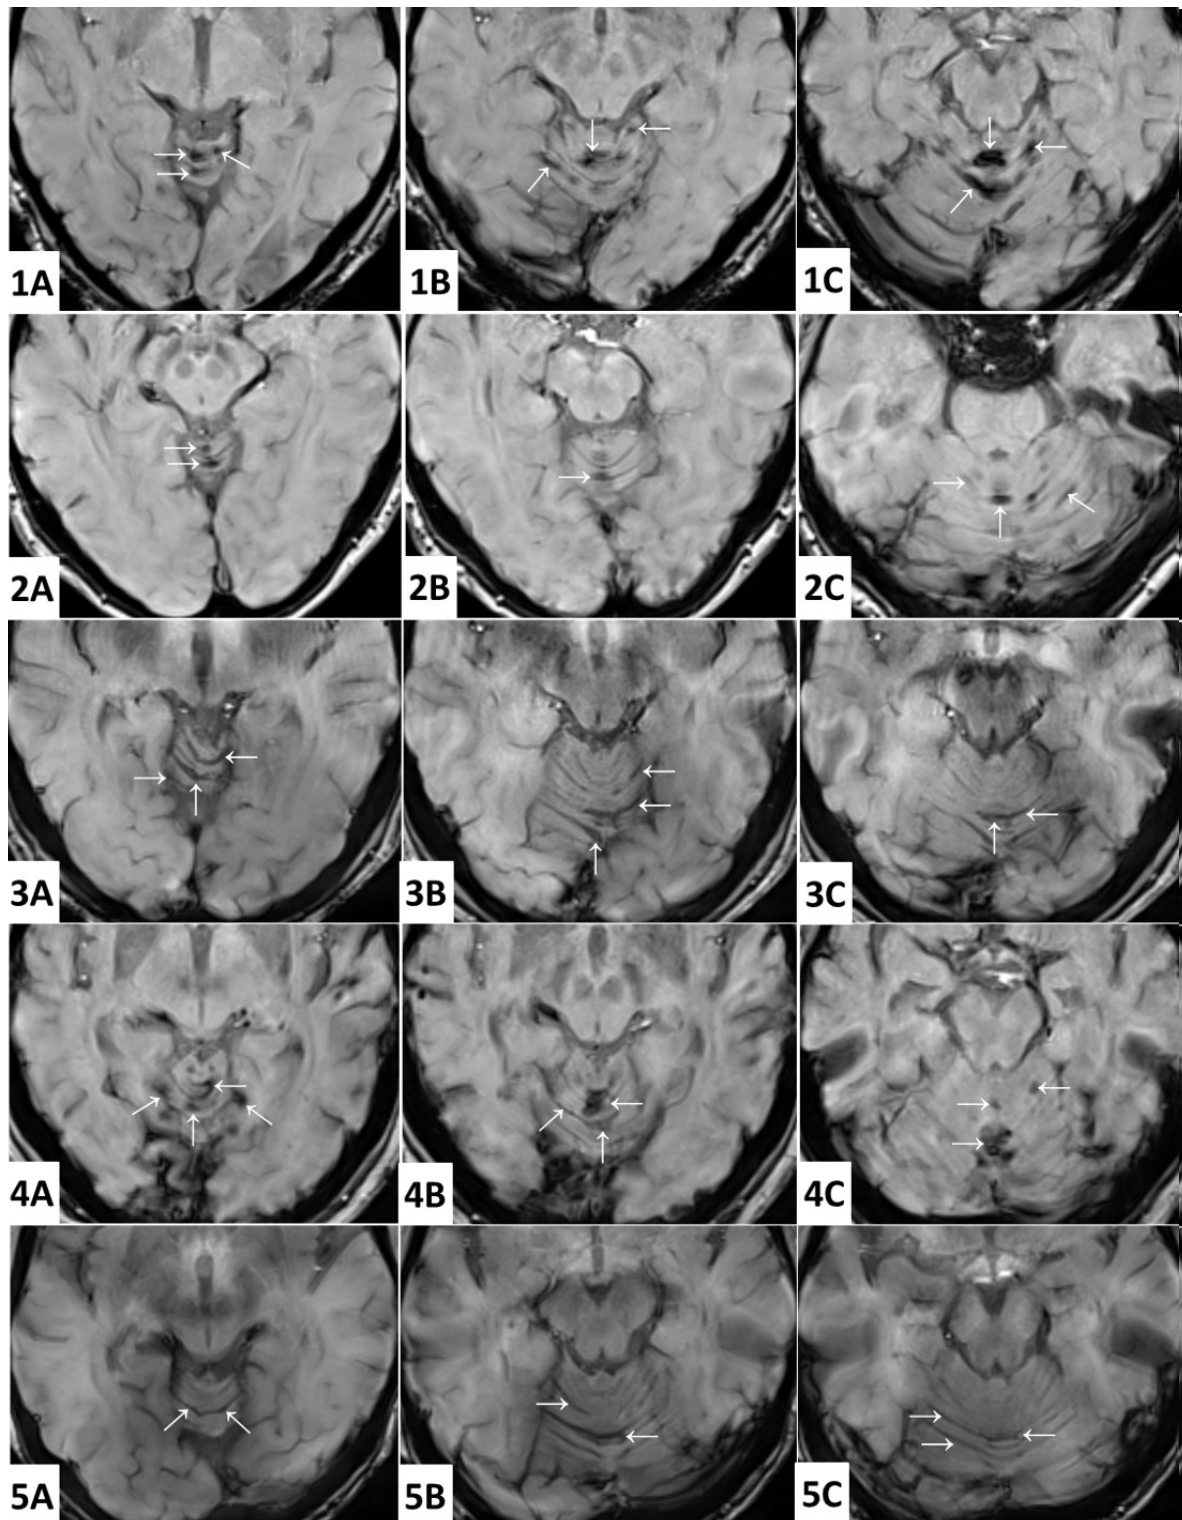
Axial susceptibility weighted magnetic resonance images of the identified cases. Appearances of the signal dropout suggestive of haemosiderin deposits are marked with arrows. Each case is numerically represented (1-5); A-C: cephalad to caudal images of superior vermis and cerebellar folia provided for each case. Images: © UK Biobank.
